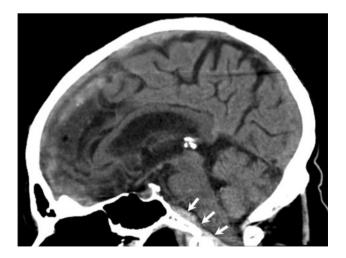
Sagittal CT image of the head without contrast shows retroclival hematoma, most likely in the epidural space, anterior to the pons, medulla, and cervicomedullary junction (*arrows*)
